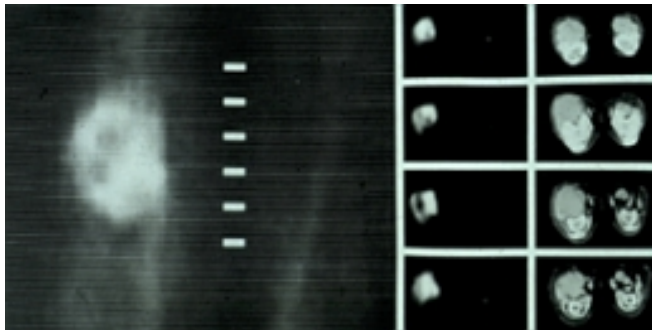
Blood flow study of soft tissue tumor in the left leg using PC-II and continuous inhalation of C^{15}O_2 . Transverse slices are correlated with corresponding CT images.
